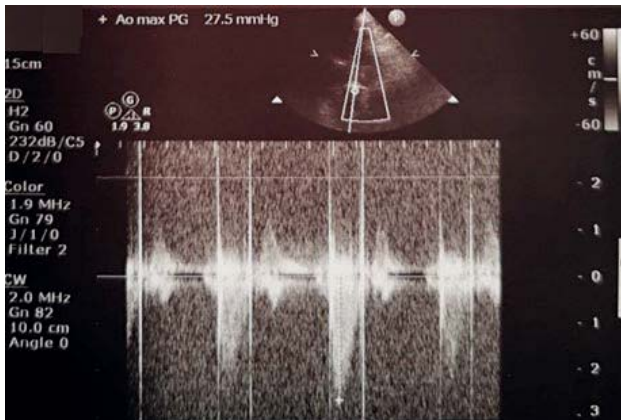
Control transthoracic echocardiography
